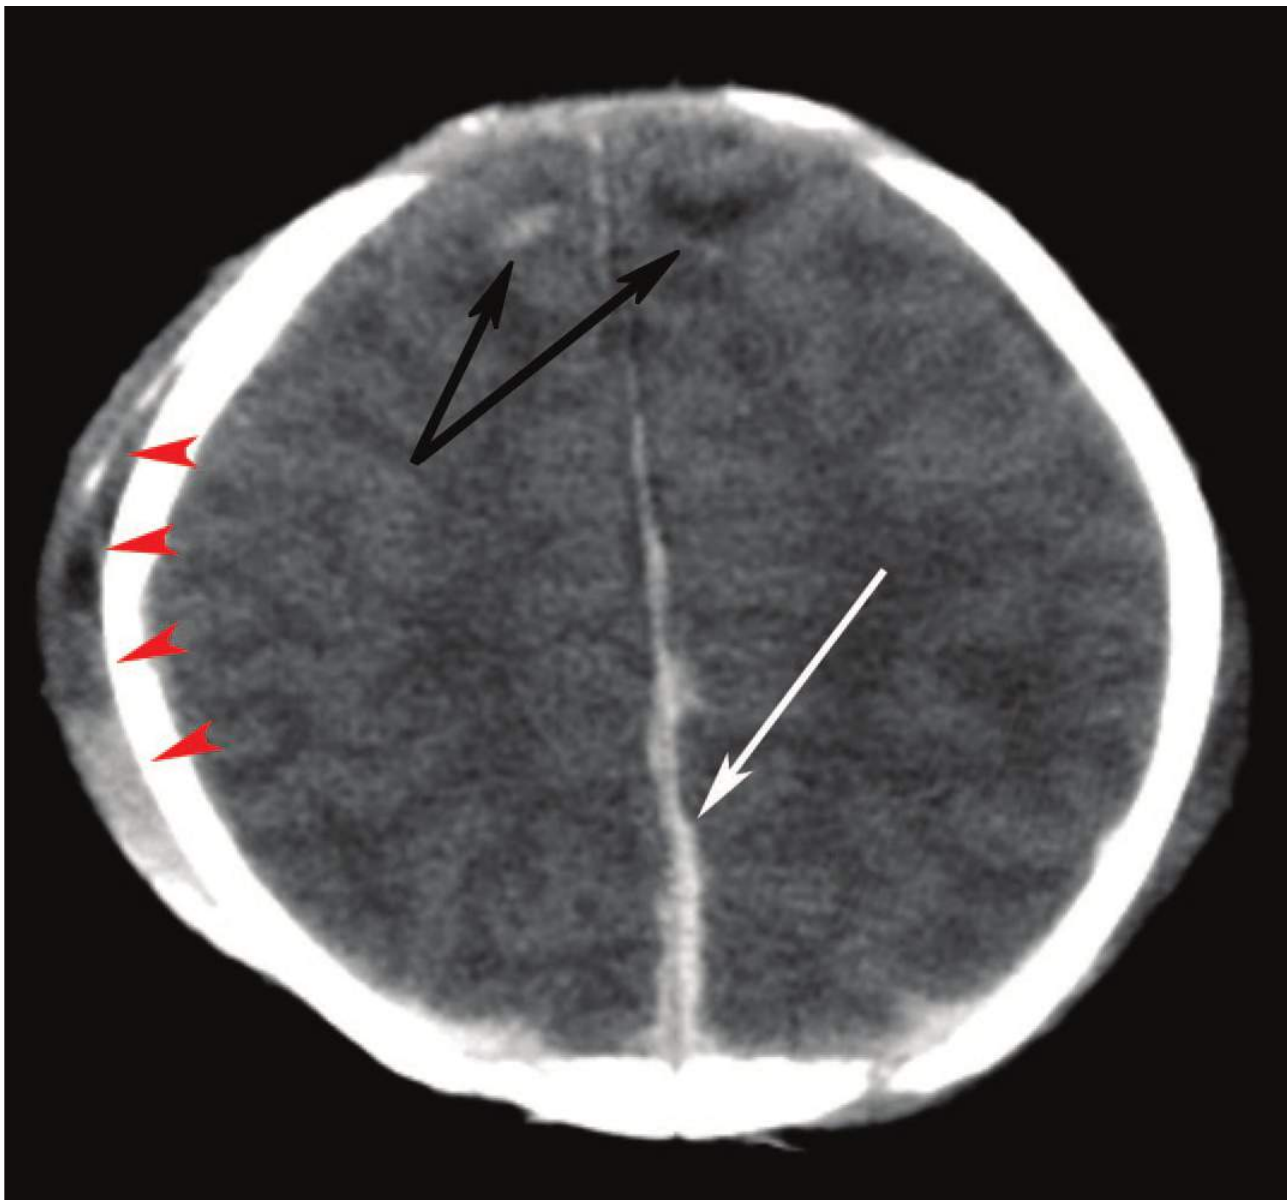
■ Subdural Hematoma and Extra-Axial Swelling. This image shows intrahemispheric acute subdural blood (large arrows) and subtle contusions (black arrows) of the frontal lobes. Extracranial soft tissue swelling (arrow heads) is also present; sometimes this is visible on CT but not on physical examination. (Photo contributor: Marguerite Care, MD.)
